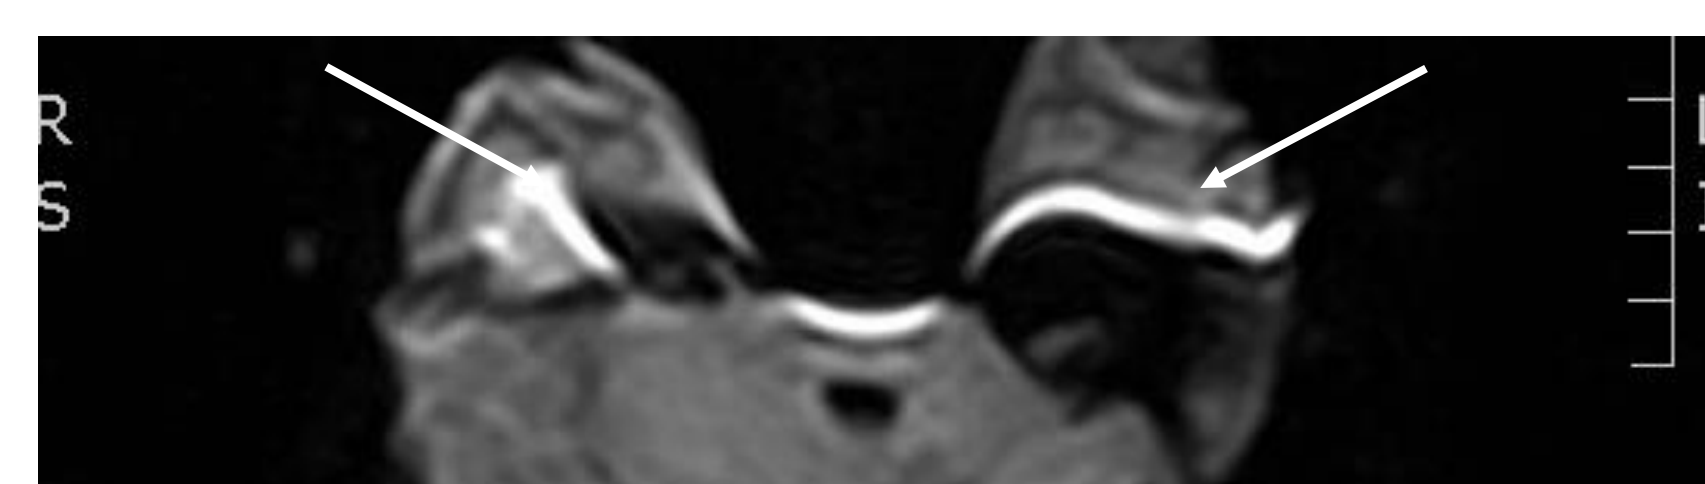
Axial DWI MRI of patient 1, initially missed by radiologist. Cholesteatomas on the floor of the MCF can be missed due to the brain/bone junction artifact (arrows)
